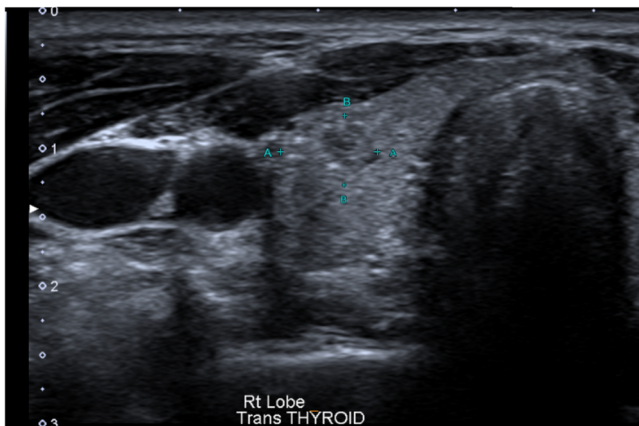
Ultrasound demonstrates a 7 mm nodule in the right thyroid lobe which is solid, isoechoic to background parenchyma, wider than tall, with ill-defined margins and punctate echogenic foci (TIRADS 4)
